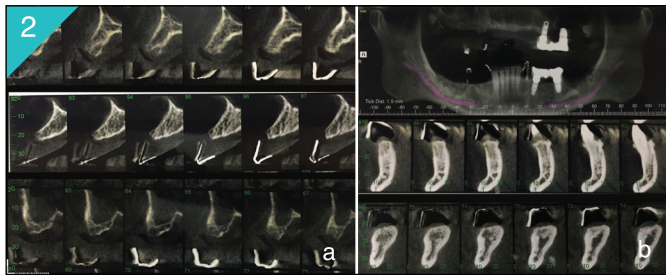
a) CBCT of the clinical situation after the removal of all compromised teeth. b) Showing the radiographic silhouettes of the denture teeth.
